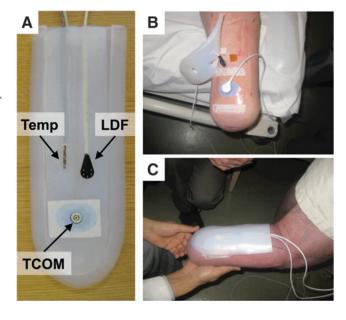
Silicone gel probe holder for in-liner measurement. (A) Temperature, TCOM, and LDF probes were embedded in a silicone gel insert to enable real-time measurement of limb temperature, oxygenation, and perfusion respectively. (B) Placement of probes on residual limb of transtibial participant. Oxygen permeable Tegaderm™ was used to adhere the TCOM probe to the limb. (C) The silicone gel insert enabled reproducible placement and spacing of probes and buffered against the liner from pressing probes tightly against skin. LDF, laser doppler flowmetry; TCOM, transcutaneous oxygen measurement.
